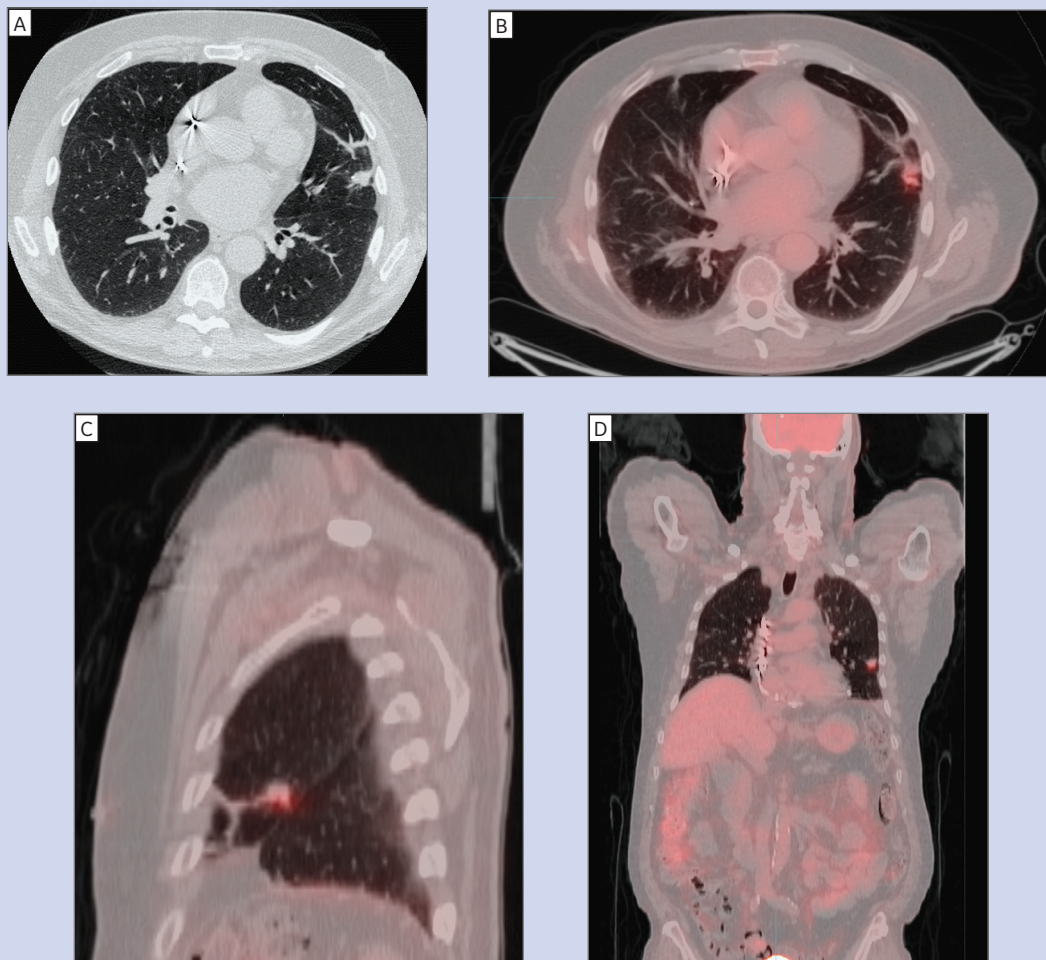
A 70-year-old man with a long smoking history was referred to the Duke Lung Cancer Screening Clinic by his internist. (A) The lung cancer screening low-dose CT performed at that time showed a 1.4 cm spiculated nodule in the left upper lobe, for which a PET was recommended. (B, C, D) PET demonstrated a hypermetabolic nodule ($SUV_{max} 2.8$) with FDG uptake above mediastinal blood pool.
